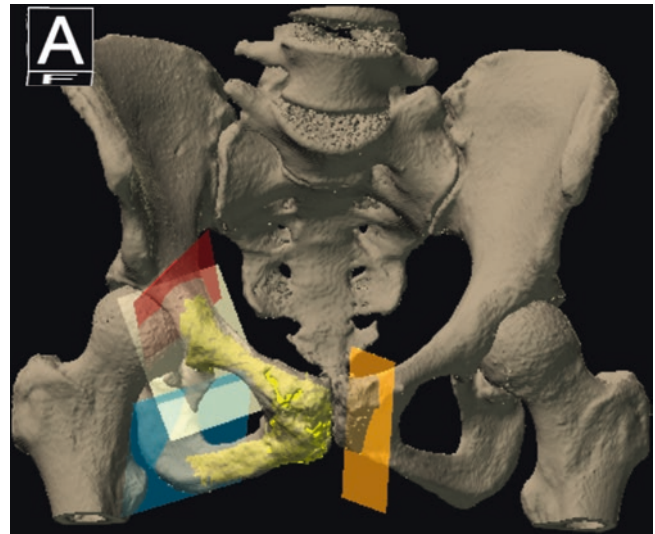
3D view of the surgical planning of the resection planes in the Orthomap oncology module with tumour coloration on the fused MRI/CT image. The MRI is hidden, and only the tumour is selected. The planes are placed using minimum distance measurements
